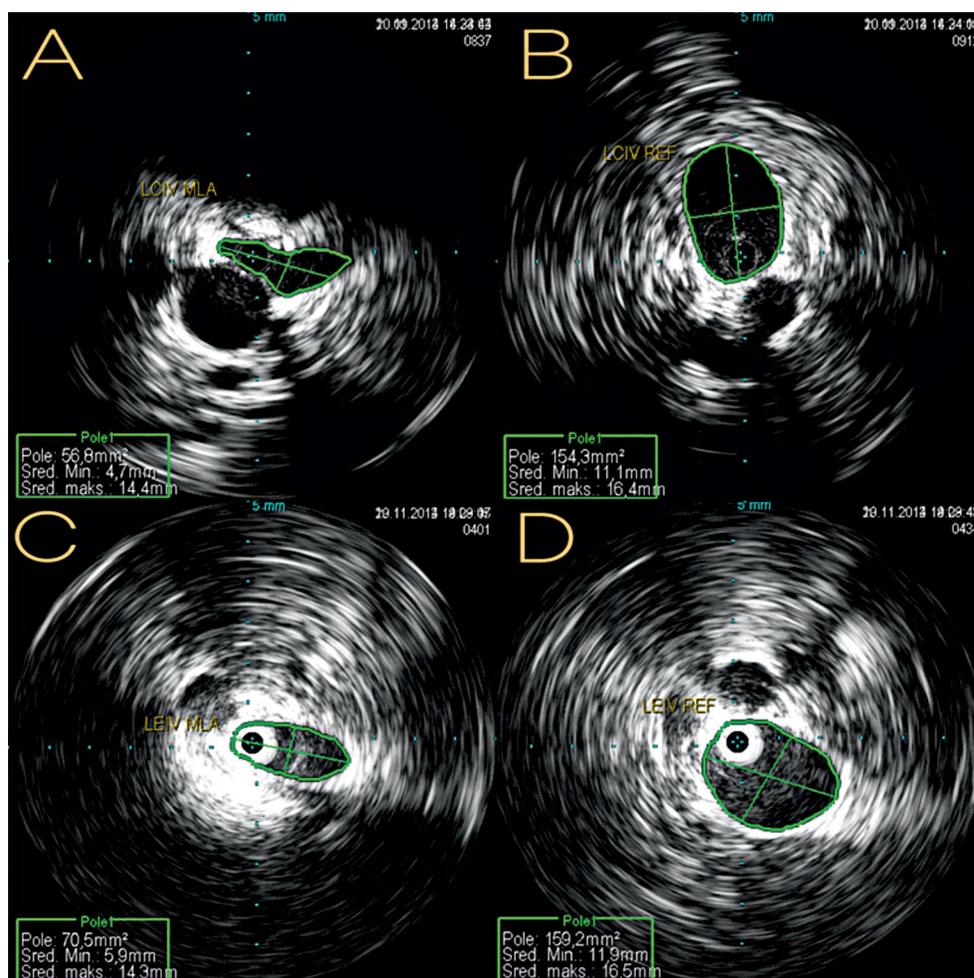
An intravascular ultrasound (IVUS) images of left common iliac vein (LCIV) and external iliac vein (LEIV) showing a minimal lumen area (MLA) (panels A and C) and a reference cross-sectional area (REF) (panels B and D)
